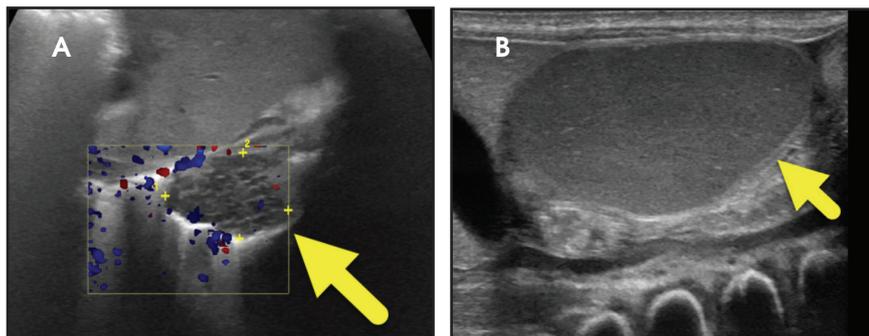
Ultrasound images at birth (A) show hypoechoic lung lesions adjacent to the pleura (arrow). Ultrasound images in the right upper abdomen (B) show a dilated bowel loop (arrow).
